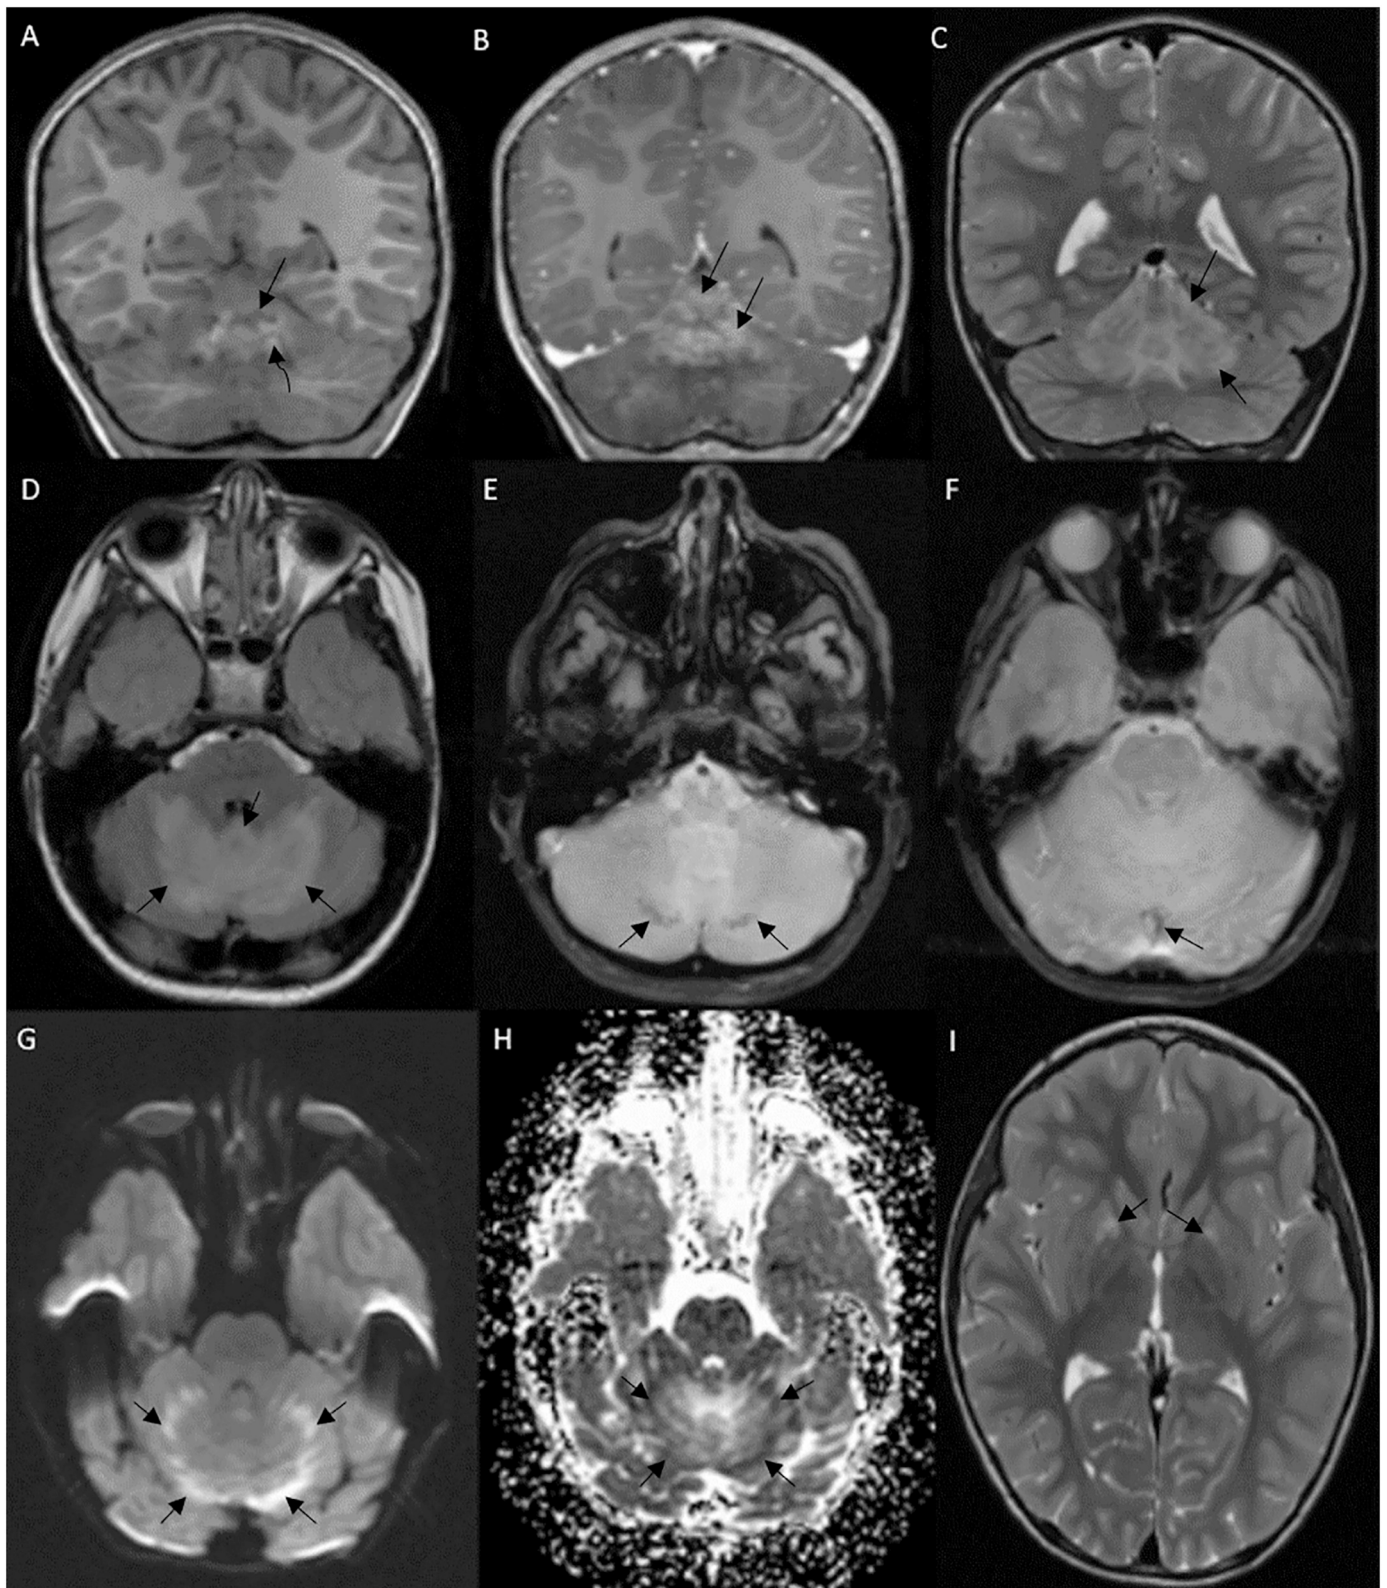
Symmetric partial superior vermis and cerebellum hemispheric affection, including cortex and white matter. Displayed images show central areas of T1 hypo and hyperintensity (A), and gadolinium enhancement (B); T2 (C) and T2 FLAIR (D) wider hyperintensity; T2* (E,F) shows peripheral hypointensity foci related to blood degradation products; (G,H) DWI and ADC map show features of peripheral restricted diffusion; (I) Symmetric lenticular anterior-inferior T2 hyperintensity (similar findings on follow-up exam). There was no evidence of the typical restricted diffusion on the basal ganglia (DWI and ADC map not shown).
